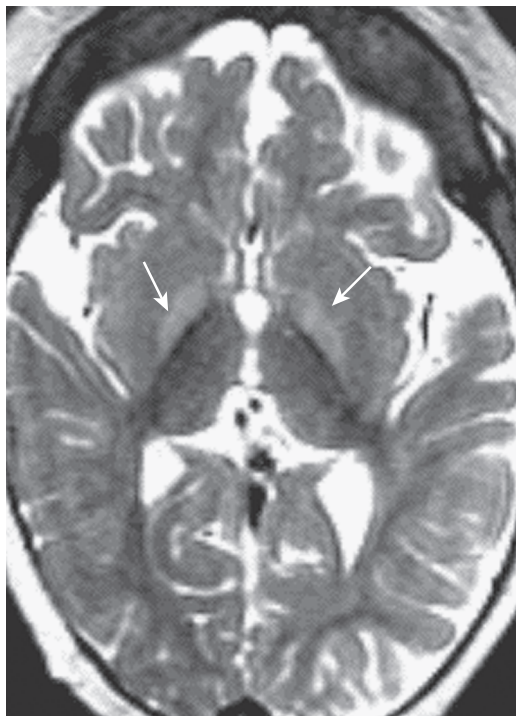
Pantothenate kinase-associated neurodegeneration with characteristic bilateral high- and low-intensity globus pallidus lesions (*arrows*) on axial GRE MR image.
